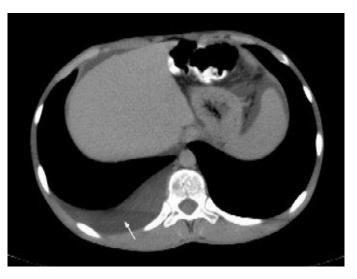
Follow up abdomen CT scan of a 22 male patient with renal lymphangiectasia. The examination was done by Brilliance 64 Philips machine; kV 120.0, mAs 246 and 3 mm slice thickness. Oral contrast and 70 ml IV contrast (Ultravist) were given. The axial contrast enhanced section in the excretory phase at level of the upper abdomen shows relative improvement in the Rt. pleural effusion (arrow).
